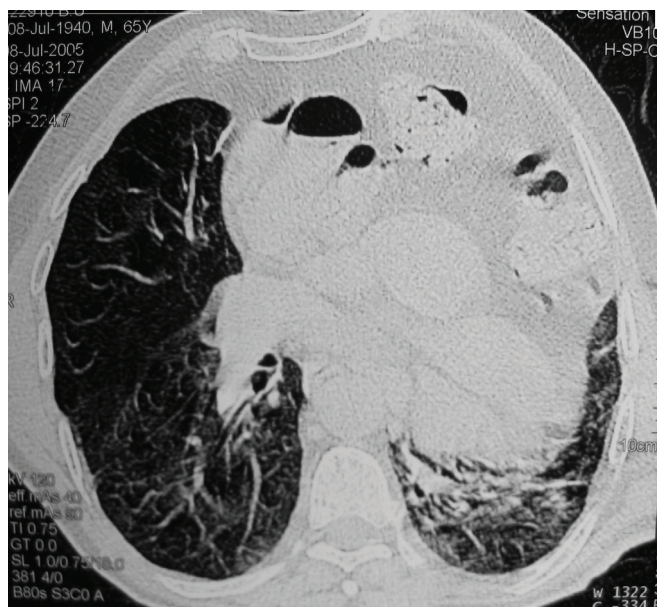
Preoperative computed tomography (CT) scan. Abdominal organs (transverse and descending colon, omentum, and gastric fundus) are seen filling the thoracic cavity and anterior mediastinal area. The heart and great vascular structures are displaced to the posterior mediastinum by the pressure of the abdominal organs. Atelectatic lower-lobe segments of the left lung are seen in the CT scan.
